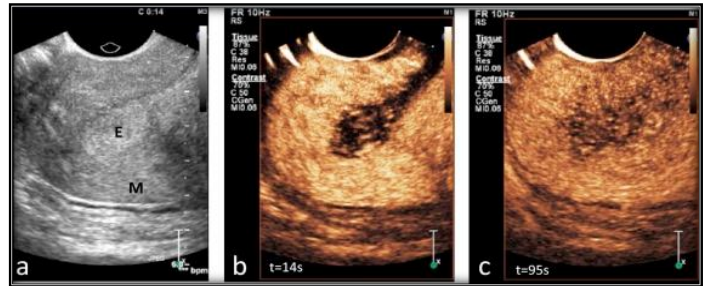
Contrast-Enhanced Ultrasound in the Assessment of Uterine Fibroids
